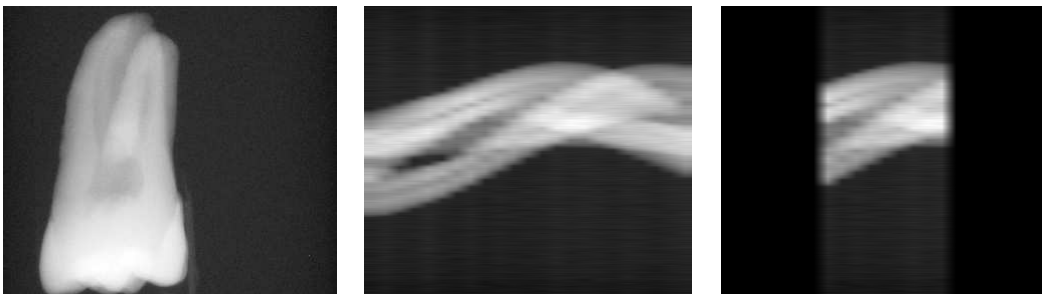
Left: A projection radiograph of the tooth. Middle: One 2D slice of the full-angle data (23 projections spanning a view angle of  $187^\circ$ ) in sinogram form. Right: Corresponding slice of the limited-angle data (9 projections spanning a view angle of  $68^\circ$ ) in sinogram form. The black parts on left and right denote the missing parts of the sinogram.
